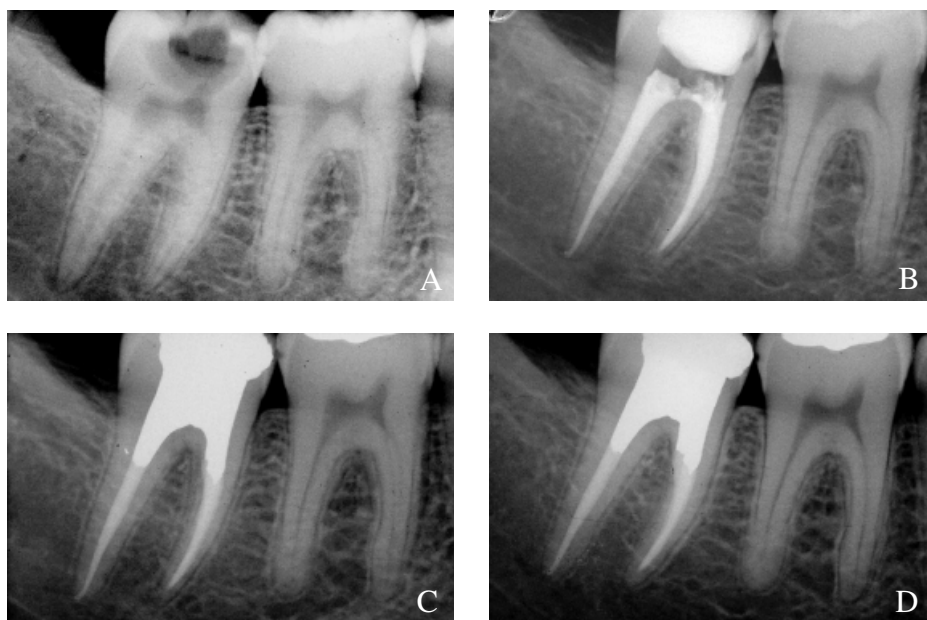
Pulpectomy of tooth #47 because of a carious exposure of the pulp. (A) Preoperative radiograph showing a small osteolytic lesion on the distal root. (B) Immediate postoperative control showing a small overfill of the distal root. (C and D). Two- and three-year postoperative control radiographs show normal periapical bone structures and disappearance of the overfill.
